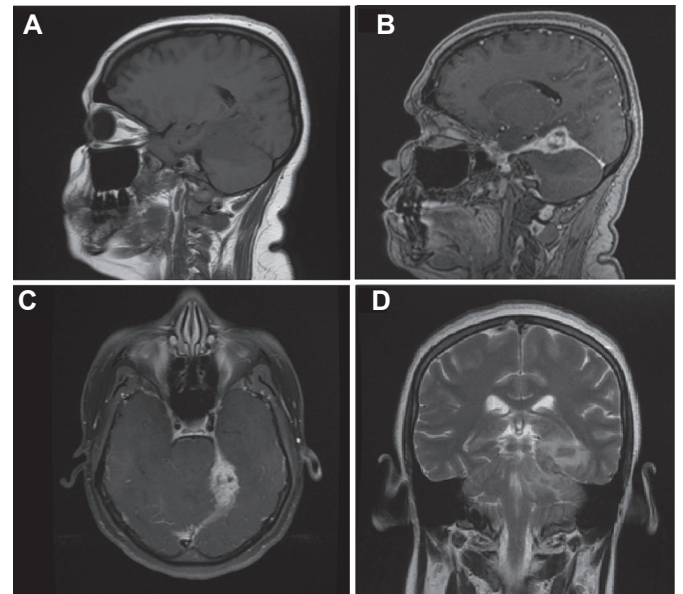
Extra-axial expansive nodular formation in the left tentorium. The lesion has predominantly low signal intensity on A) T1- and D) T2-weighted images, and (B, C) presents irregular and intense enhancement after intravenous contrast associated with the dural tail signal, making meningioma a challenging differential diagnosis of brain tuberculosis. Note also that a T2 hyperintense area adjacent to the lesion can be observed in the left temporal lobe and on the vermis, consistent with edema.
